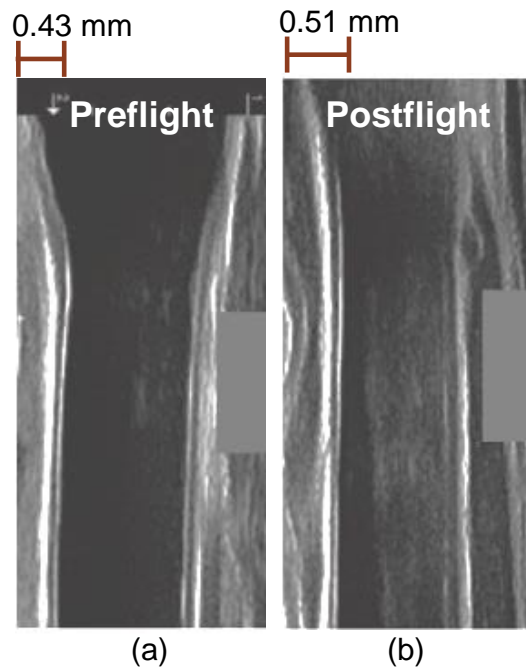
Ultrasound image (adapted from [1]) of the common carotid artery measured proximal to the carotid bulb in an astronaut (a) preflight, and (b) after 6 months of spaceflight. The difference in wall thickness is equivalent to more than 20 years of normal aging.
